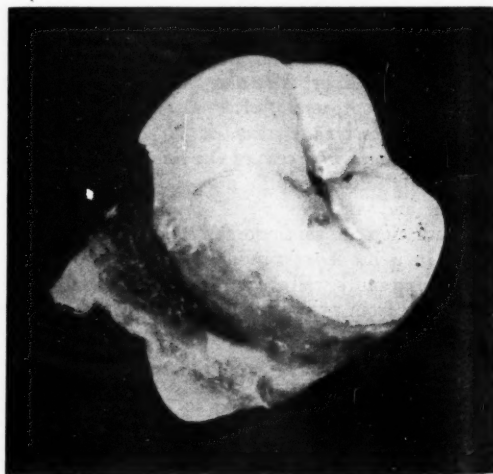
Portion of tooth removed from the right lower lobe bronchus of patient whose radiograph is shown in Fig. 1.
